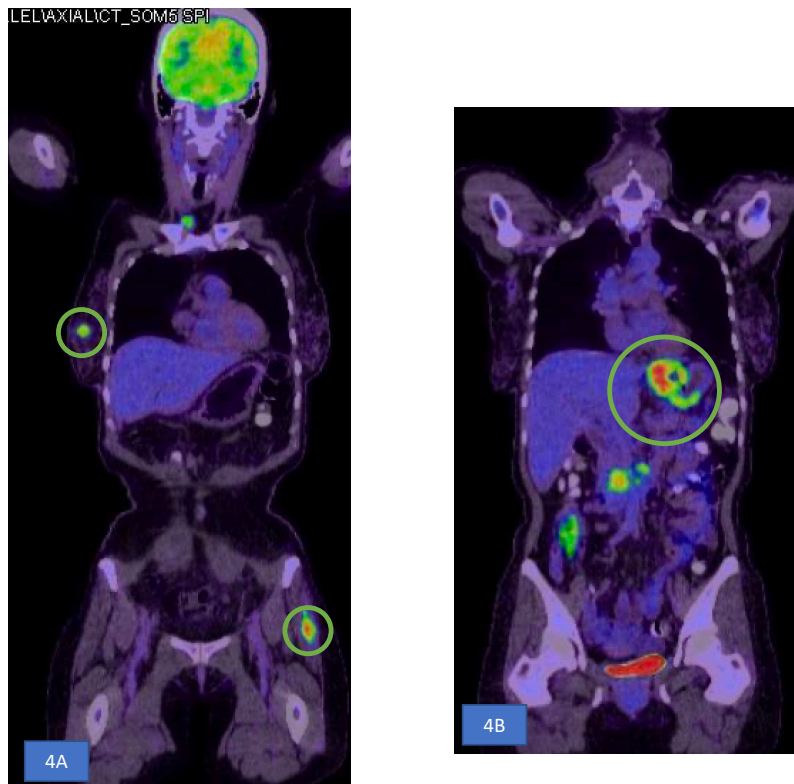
and 4B: Patient 4: PET CT scan showing avid uptake in the right breast and the skeletal muscles in the left side (green circle).
